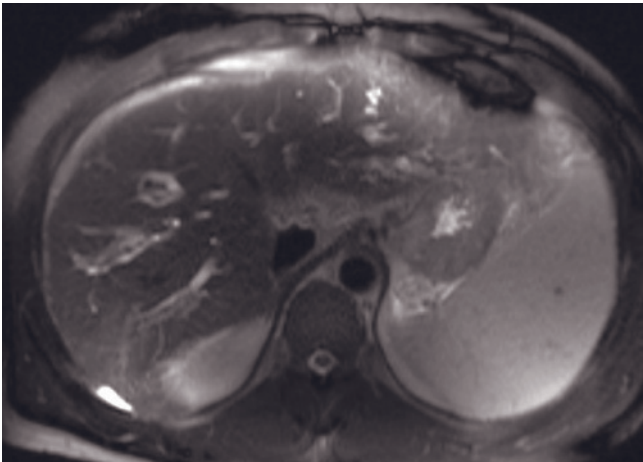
Primary sclerosing cholangitis. T2-weighted fat-suppressed SS-ETSE (*a*), SGE (*b*), immediate (*c*) and 90-second fat-suppressed (*d*) postgadolinium SGE; T2-weighted fat-suppressed SS-ETSE (*e*), SGE (*f*), and immediate (*g*) and 90-second fat-suppressed (*h*) postgadolinium SGE images in two patients with PSC. T2-weighted fat suppressed SS-ETSE fat suppressed (*i*, *k*, *n*)
